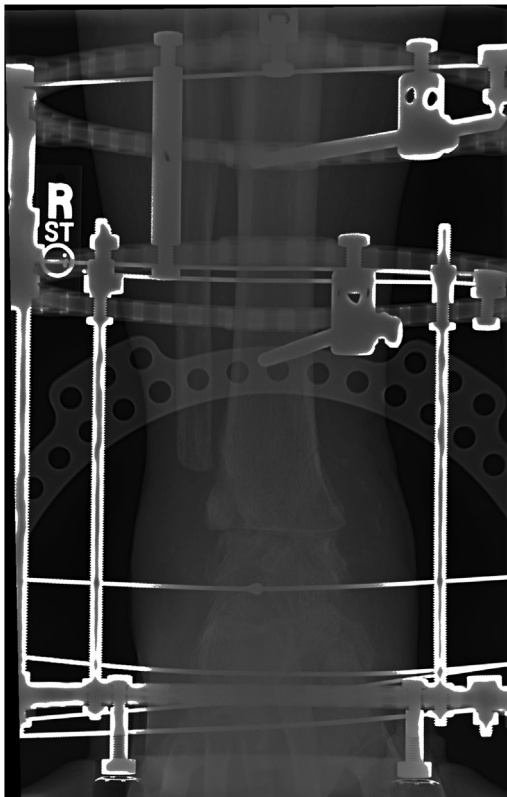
AP ankle radiograph 3 weeks after thin-wire external fixator placement used for revision ankle arthrodesis.
